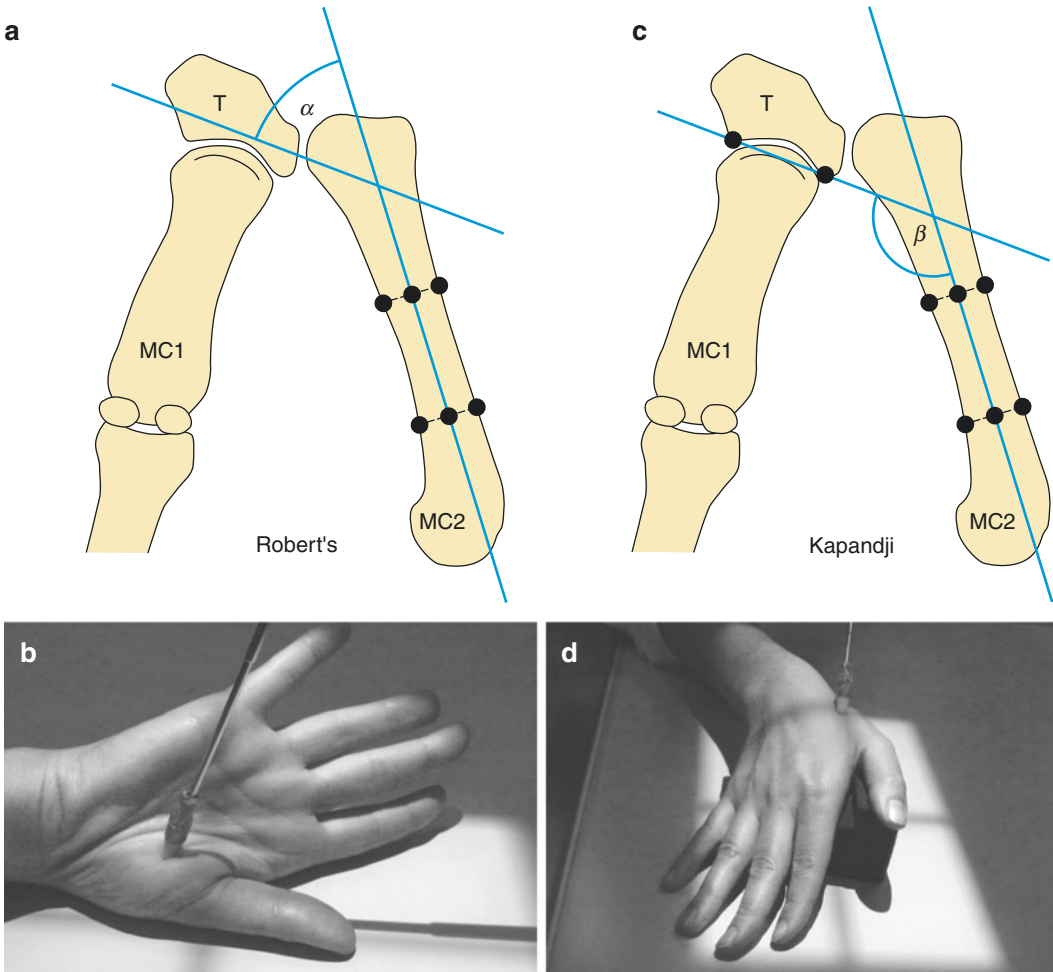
Trapezial tilt angle measurement using the Roberts (a) and Kapandji (b) methods and the corresponding respective radiographic positions for obtaining them (c, d)
